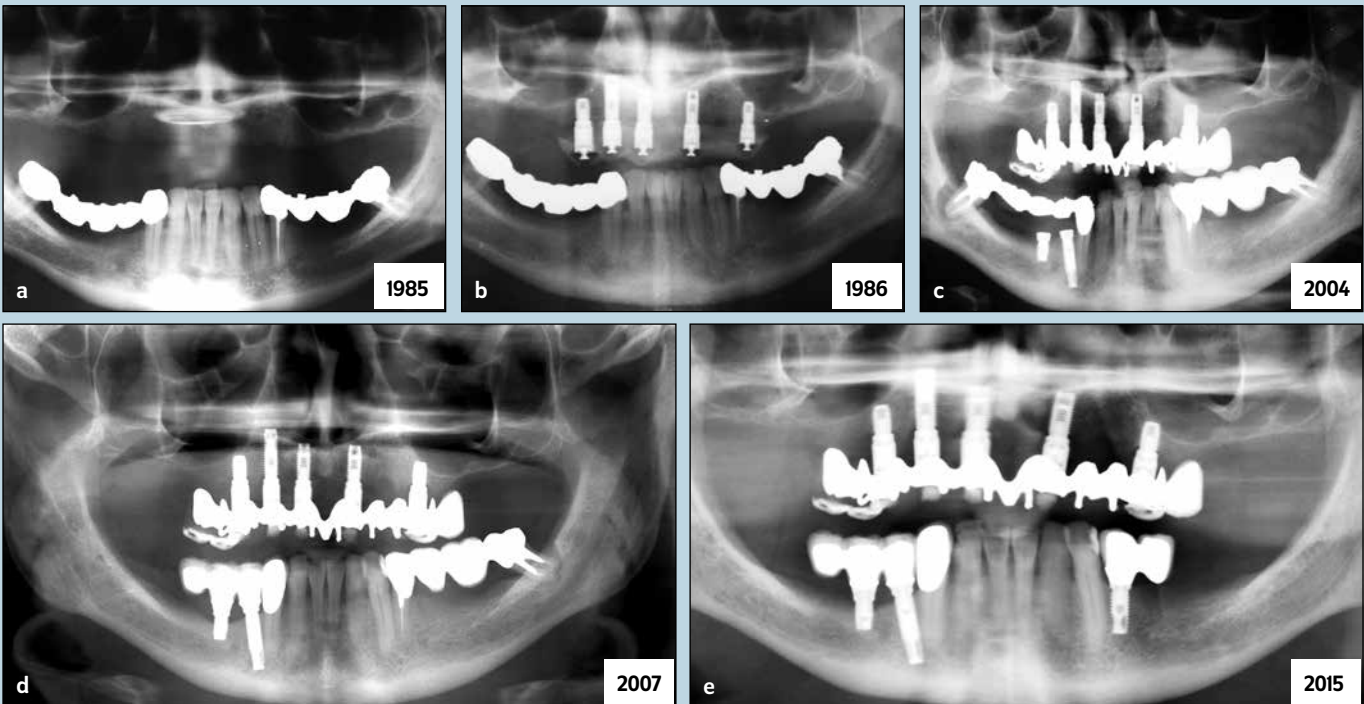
(a to e) Panoramic radiographs show 30 years of follow-up of a patient treated with a Toronto-Brånemark maxillary prosthesis. Over the years, the mandible has undergone various interventions, such as the replacement of dental-supported fixed prostheses with implant-supported fixed partial dentures. (Courtesy of Dr Federico Gualini, Bergamo, Italy.)
